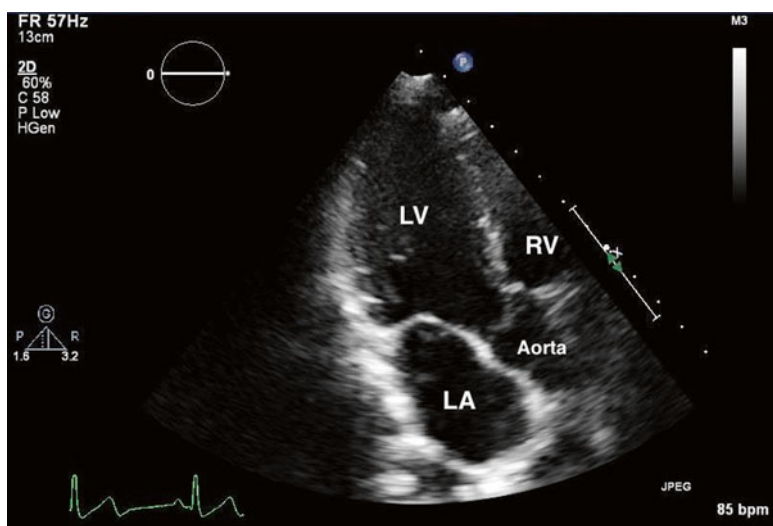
Apical long-axis view. Clockwise rotation from the apical four-chamber position results in a long-axis image displaying the left ventricular outflow tract, the aortic valve, and the base or root of the aorta (Aorta). This view is comparable to the parasternal long-axis view, rotated visually clockwise 90°
